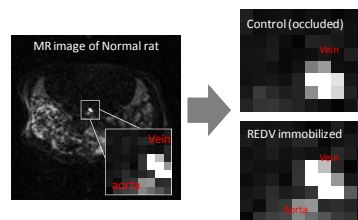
Non-invasive evaluation of the transplanted acellular small-diameter vascular grafts under MRI.  $T_r=30$  msec.
